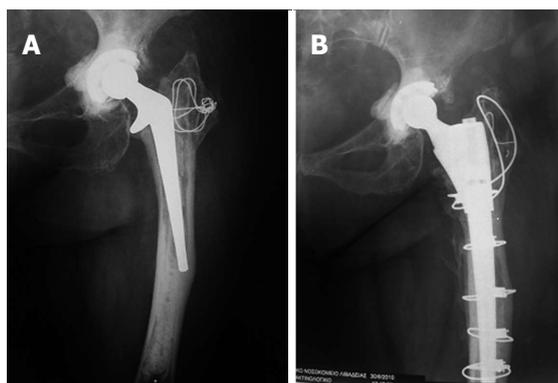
Multiple osteotomies allow for restoration of the anatomical axis of the femur, an easier access of the distal segment of the modular stem, thus reducing the risk of femoral fracture or perforation of the cortex. A: Anteroposterior (AP) radiograph of the left hip showing a cemented femoral component that is failed in varus, resulting in a slight angular malalignment of femur; B: AP radiograph of the same hip after revision of the femoral component using a modular stem, which combines both proximal metaphyseal and distal fixation due to the taper design and the distal flutes. A healed corrective osteotomy at the level of the mid-diaphysis facilitated the insertion of the stem and correction of the angular deformity to its neutral axis.
